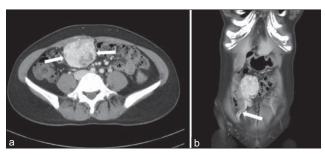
Abdominal computed tomography showing a well-circumscribed tumor mass attached to the rectus muscle and sheath. Axial (a) and coronal (b) contrast-enhanced computed tomography scans showing a heterogeneous enhancing mass (arrows in a) that displaces small bowel and also serpentine vessels near the mass is seen (arrow in b)
